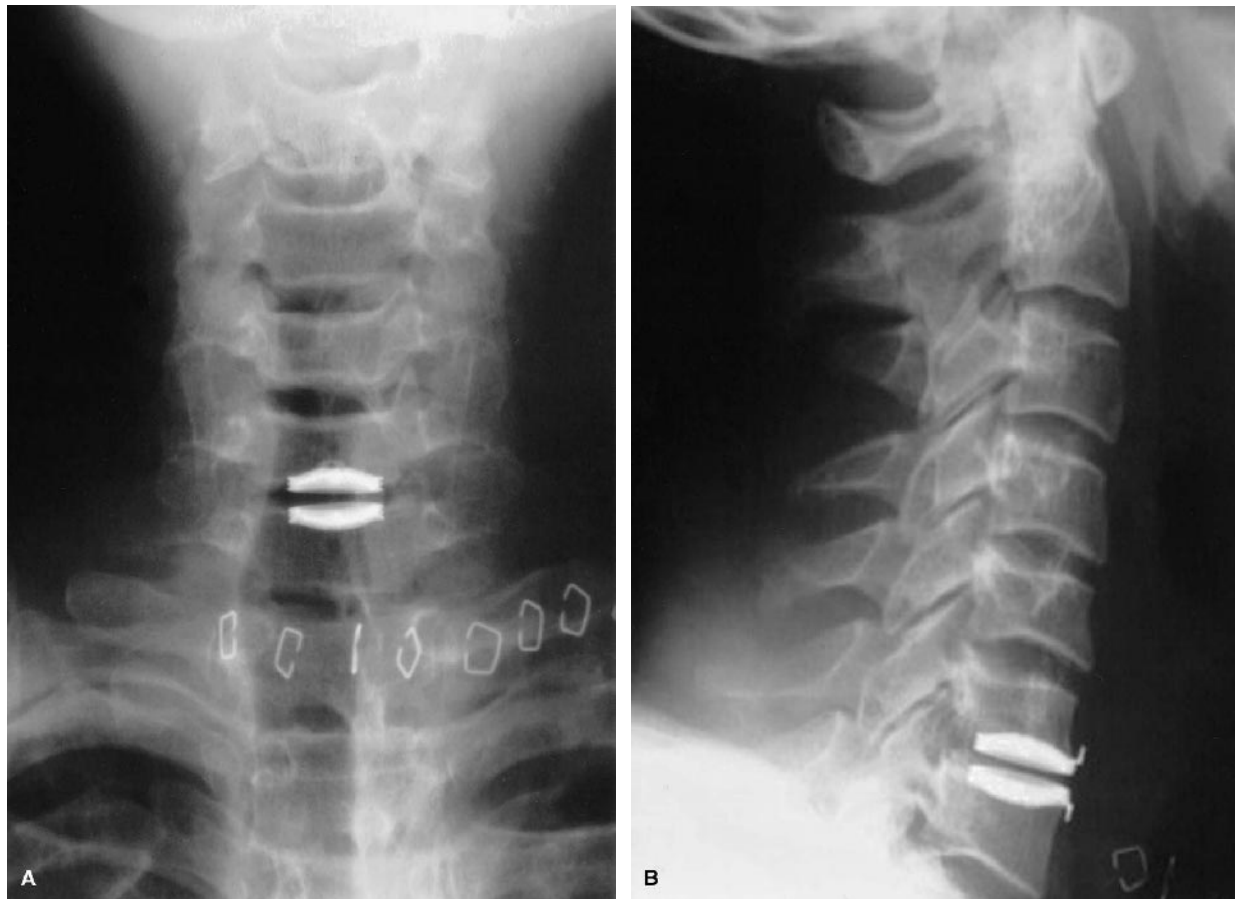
Postoperative anteroposterior (A) and lateral (B) x-rays after placement of an artificial disc prosthesis at the C6-C7 level in case 3. The prosthesis is centered on the disc space. Minimal change in disc height occurs compared with preoperative films.
